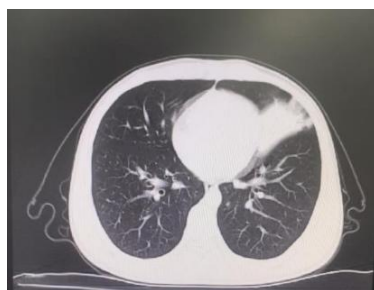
Lung CT showed bronchiectasis in the upper lobe of both lungs combined with infection
